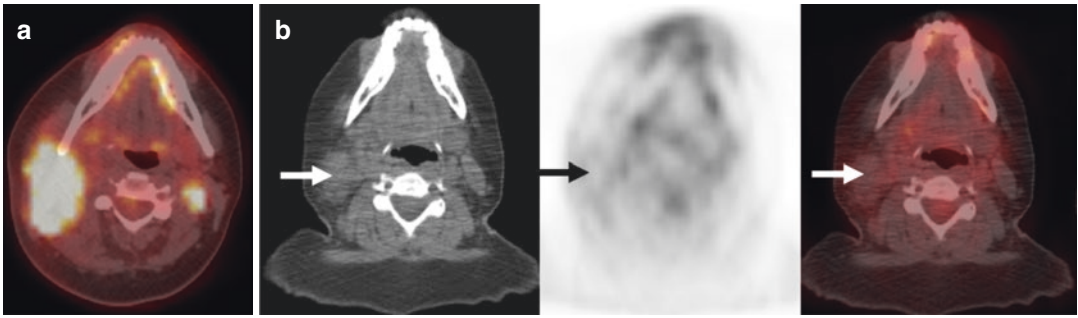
(a) Baseline FDG-PET/CT in a patient with diffuse large B cell lymphoma showed intensely FDG-avid right cervical adenopathy. (b) End of therapy PET/CT demonstrated a residual mass in the right neck with FDG
